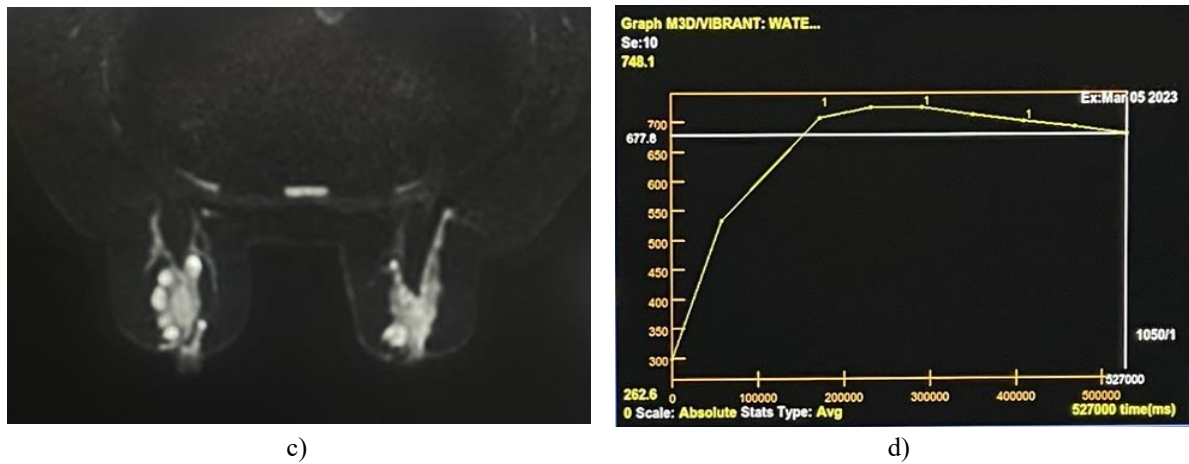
a-c) MRI images reveal a well-defined, circular mass, and d) The lesion demonstrates rapid enhancement followed by a slower washout pattern (type 3 on the kinetic curve), which is concerning for malignancy.
